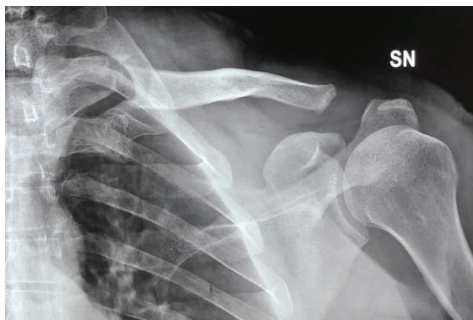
After x-ray it was suggested to wear BSO brace for 7 days and then repeat x-ray.
